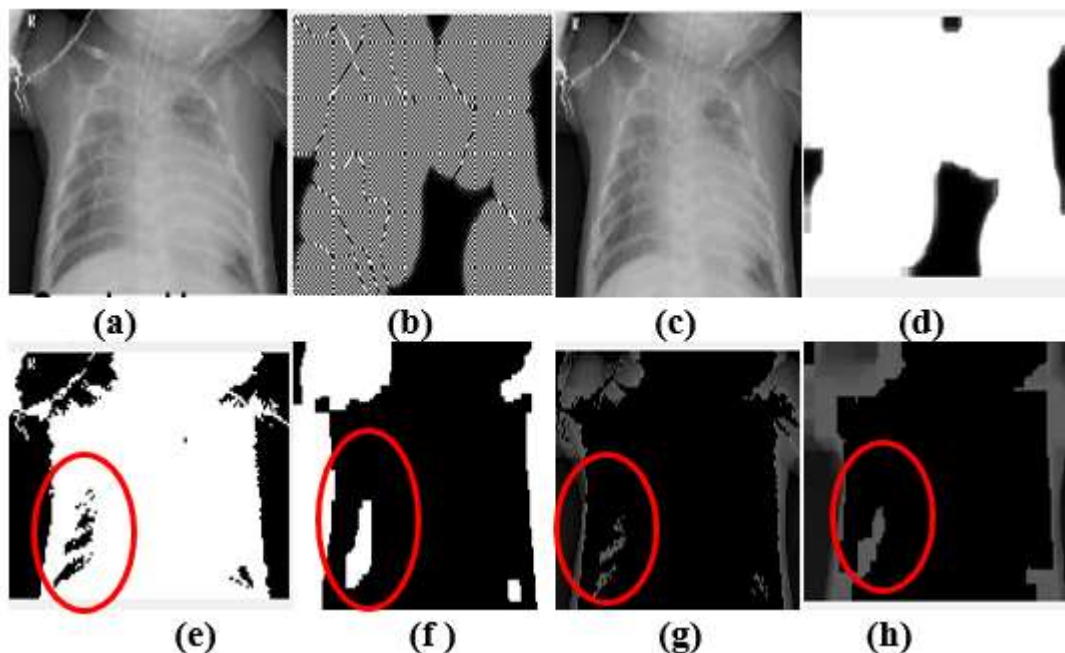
(a) -(h) Spread occurs throughout the lungs within Six days -Chest X-ray, image parameter extracted through
